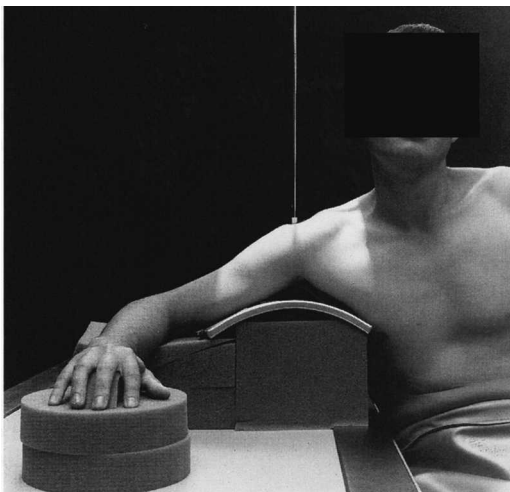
The technique for taking an axillary view radiograph is shown.
